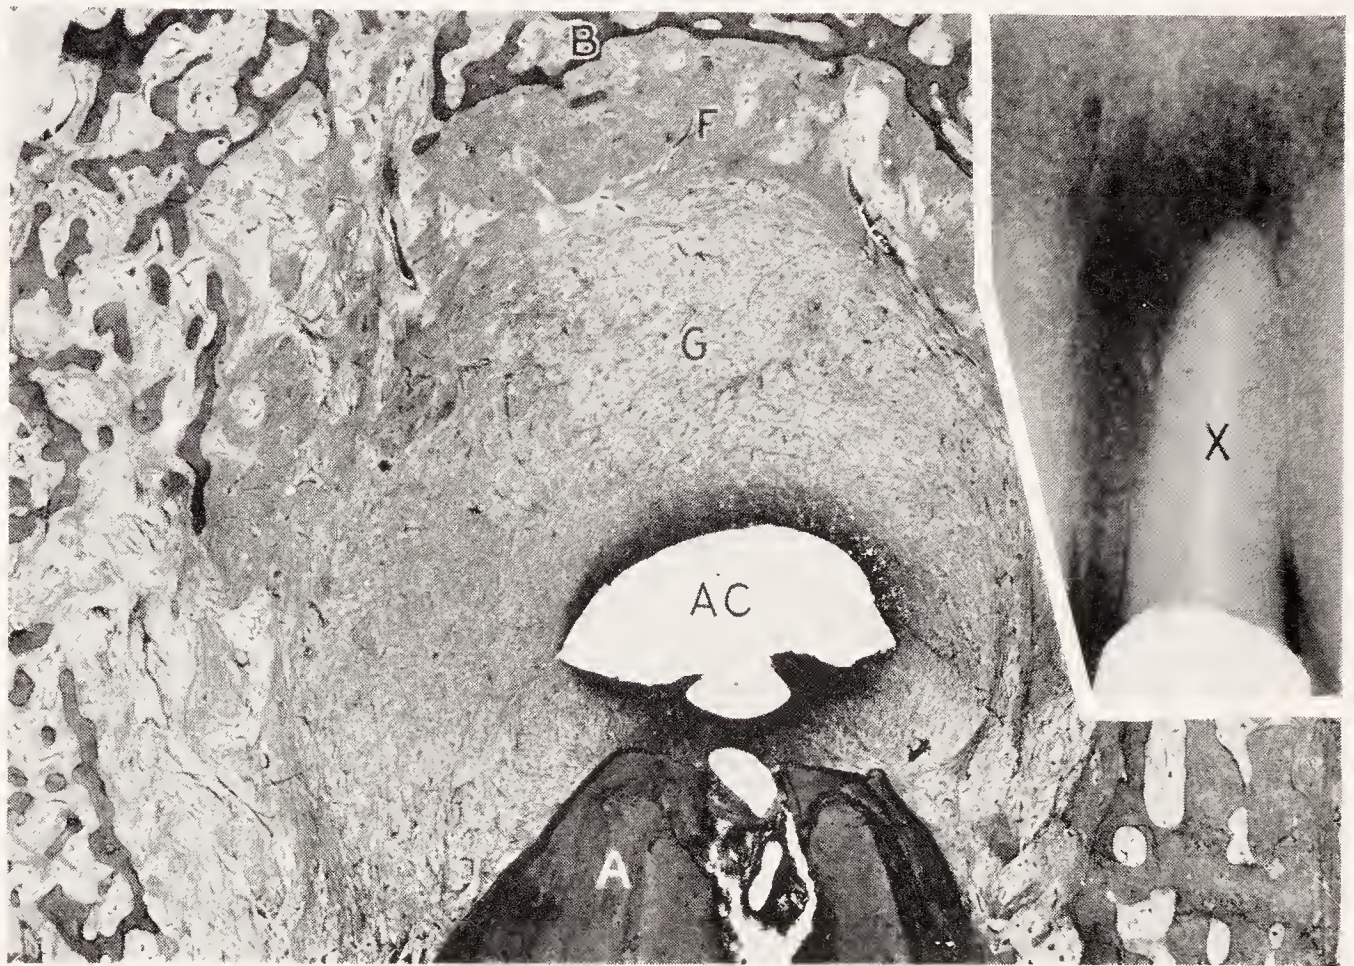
Granuloma with central liquefaction. No epithelium is present. The radiograph shows a diffuse area of bone destruction above the apex of an upper central incisor. Age, fifty-two years. *A*, apex; *AC*, abscess cavity containing pus cells; *G*, granulation tissue; *F*, fibrous tissue; *B*, bone trabeculae. (Kronfeld, Australian Dental Congress.)
